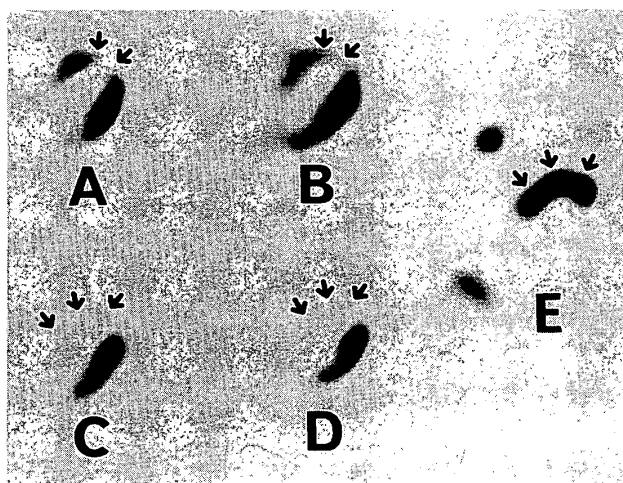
Serial thallium-201 myocardial scintigrams (A-D) and technetium-99m pyrophosphate scintigram (E). All images are transaxial tomograms at the same level with a 30% background subtraction. (A) Stress thallium-201 image obtained before and at the onset of chest pain. Perfusion defect is noted in the apical anterior wall and apex. (B) Rest thallium-201 image of dual emission computed tomography obtained 4 days later. Stress (C) and delayed (D) thallium-201 images obtained 3 weeks later. (E) Technetium-99m pyrophosphate image of dual emission computed tomography, which is derived from the identical level as the image (B).
